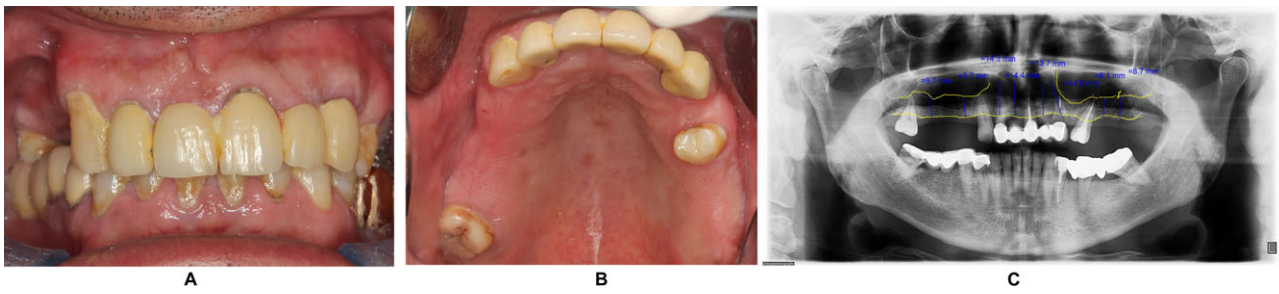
(A) Pretreatment frontal view of maximum intercuspation; (B) pretreatment occlusal view of the maxilla; and (C) pretreatment panoramic radiograph.
